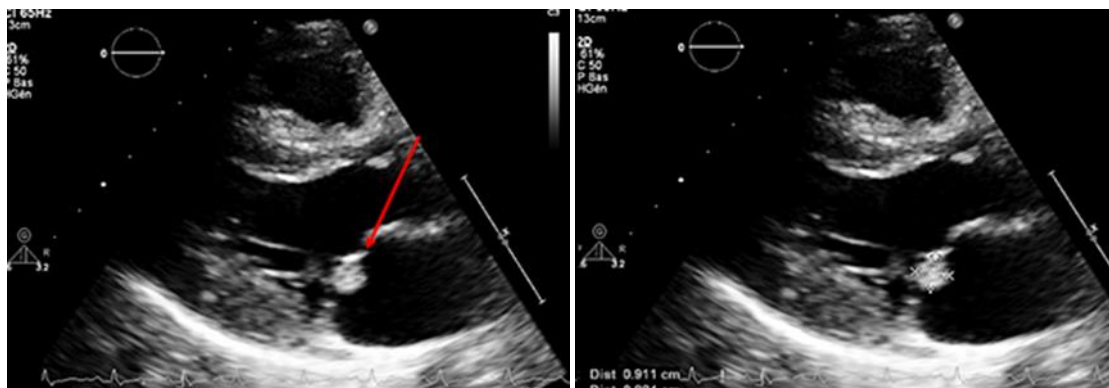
Parasternal long axis view showing vegetation in the mitral valve leaflet
